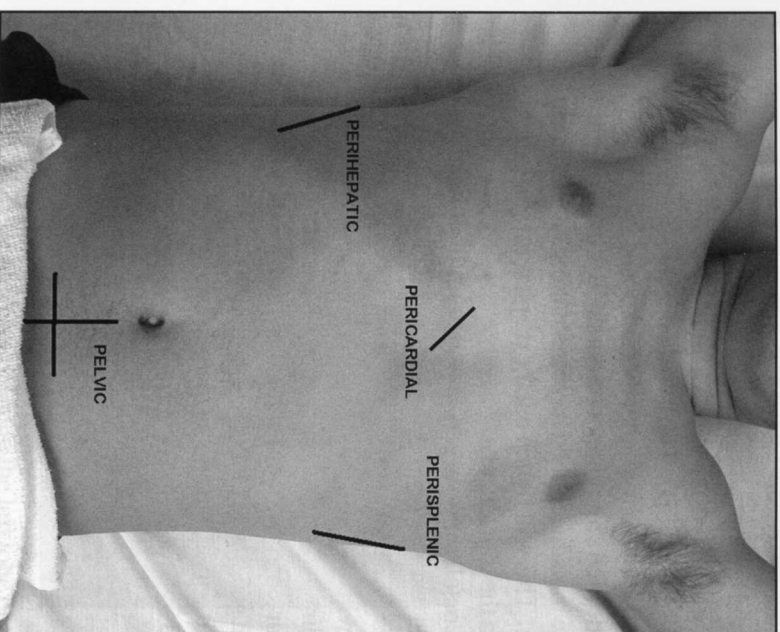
The four sonographic windows of the FAST exam.
